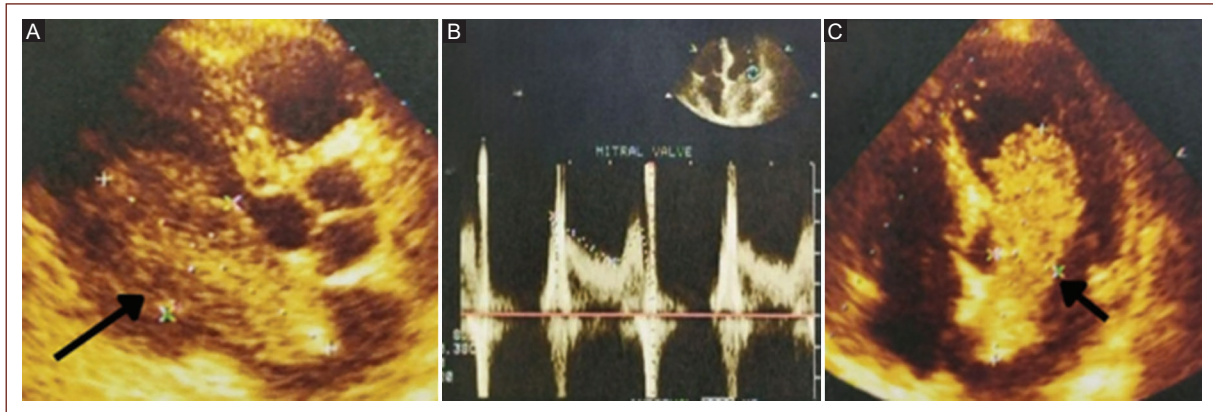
Transthoracic echocardiogram. Two-dimensional echocardiography, parasternal long axis view. A: an intracardiac mass is observed, compatible with intracardiac myxoma measuring 74×24 mm, with an implantation base at the level of the oval fossa, which protrudes into the ventricular cavity. Apical four-chamber view. B: transmitral flow is shown in pulsed Doppler mode, with a mean transmitral gradient of 3.5 mmHg, without valvular obstruction. C: an intracardiac mass is observed in the left atrium that protrudes into the ventricular cavity.
